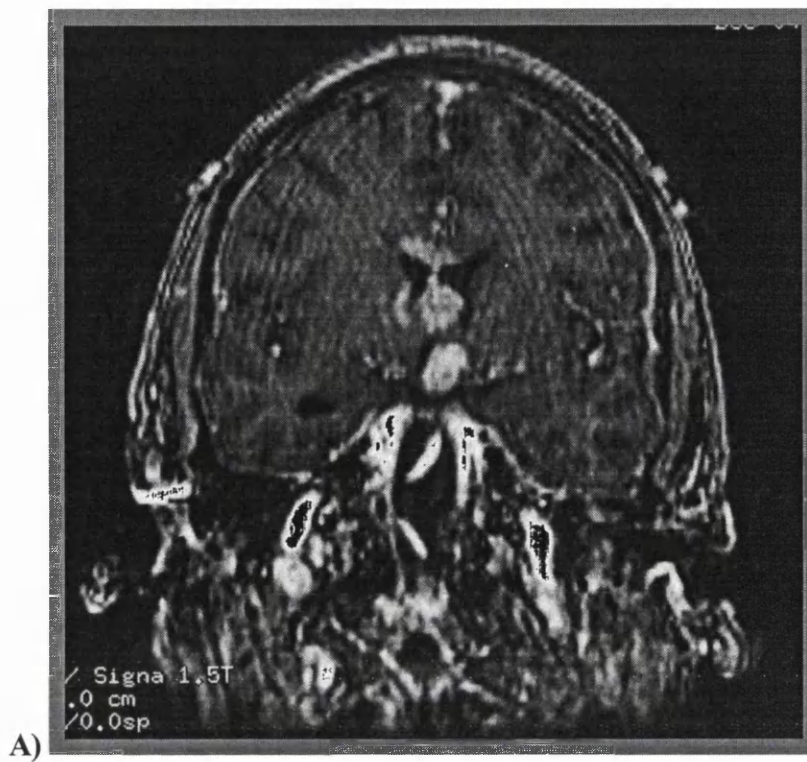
MR images of IGN Case 2 showing the vascular periventricular tumour from which transventricular biopsies were retrieved. A) Coronal and B) Sagittal views.
